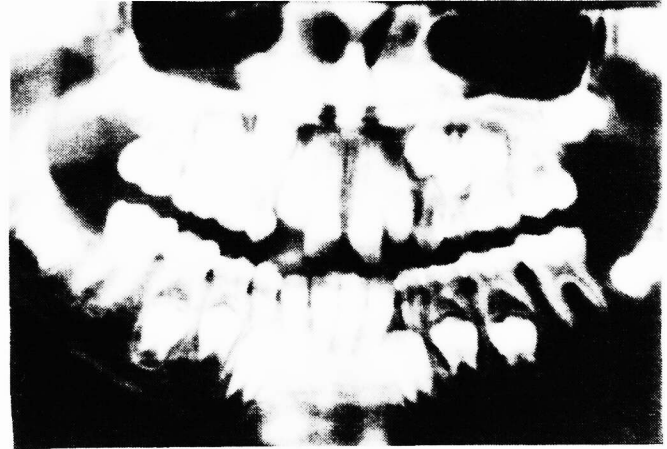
Panoramic X-ray of patient (fig 9). Observe the superior incisors area comprising the diastema.
